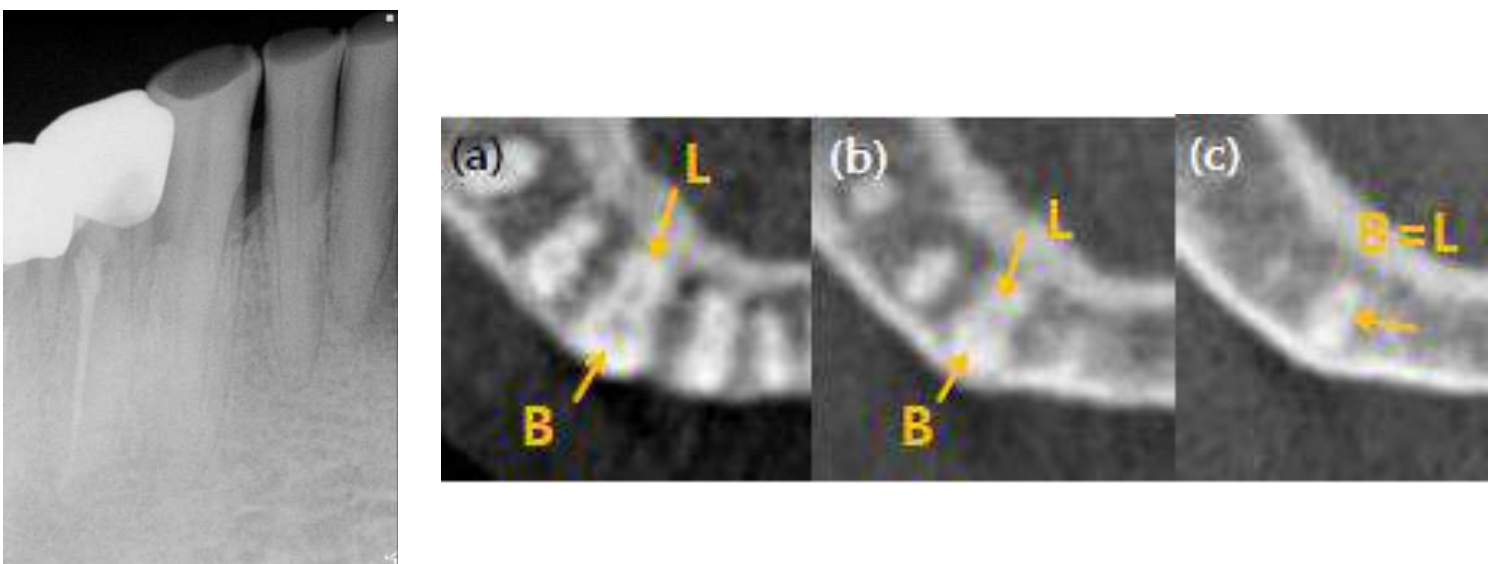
Radiography evaluation
